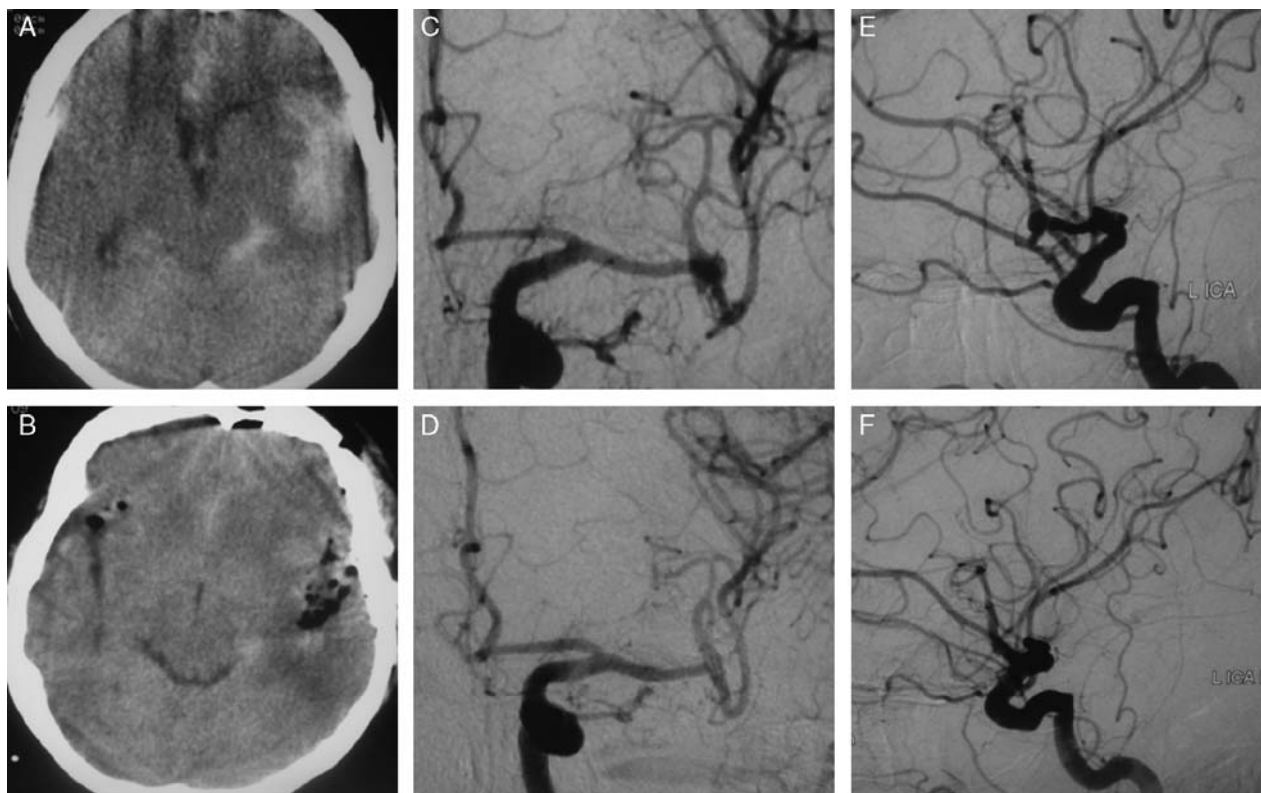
This 61-year-old male patient presented with a sudden onset of headache accompanied by loss of consciousness. A and B, A CT scan showed a left intrasylvian ICH and a subarachnoid hemorrhage. C and D, Angiography revealed a left multilobulated middle cerebral artery bifurcation aneurysm. E and F, Postoperative CT and angiography are shown after an emergency craniotomy for clipping of the aneurysm and evacuation of the ICH. He was hemiparetic and dysphasic at 6-month follow-up. CT indicates computed tomography; ICH, intracerebral hematoma.
